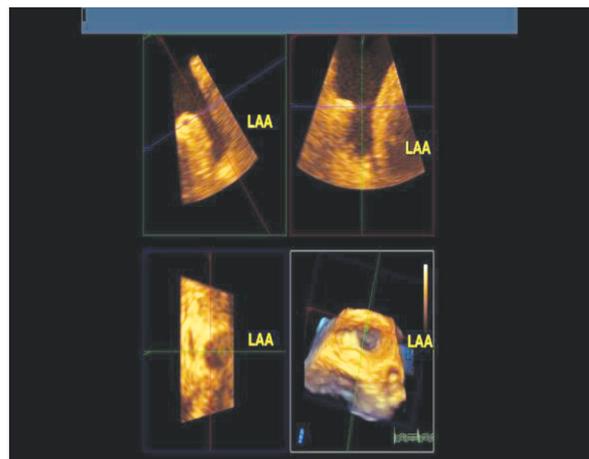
Three-dimensional transesophageal zoom image of left atrial appendage viewed in multiplanar reconstruction (MPR) mode for accurate measurement of orifice size and depth prior to Watchman procedure (arrow). LAA=left atrial appendage.
